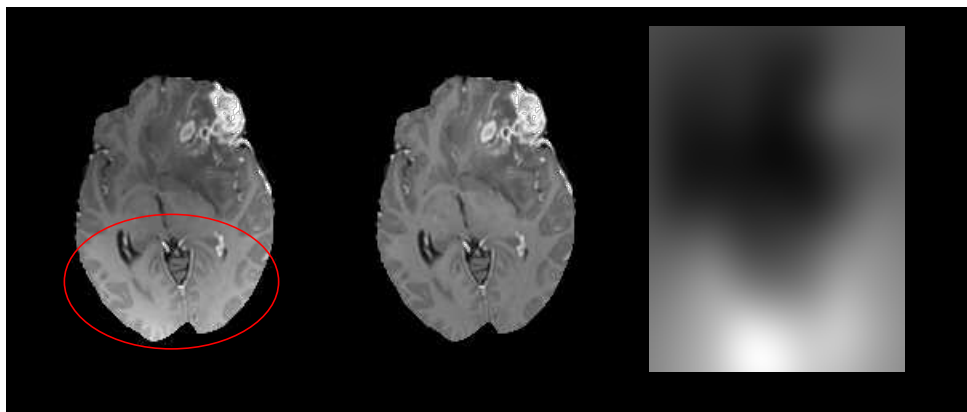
Example of bias field correction on a T_{1c} sequence. From left to right: Original T_{1c} sequence with magnetic field inhomogeneities artefact; T_{1c} sequence after the bias field correction; Estimation of the bias of the magnetic field produced by the MRI machine.
